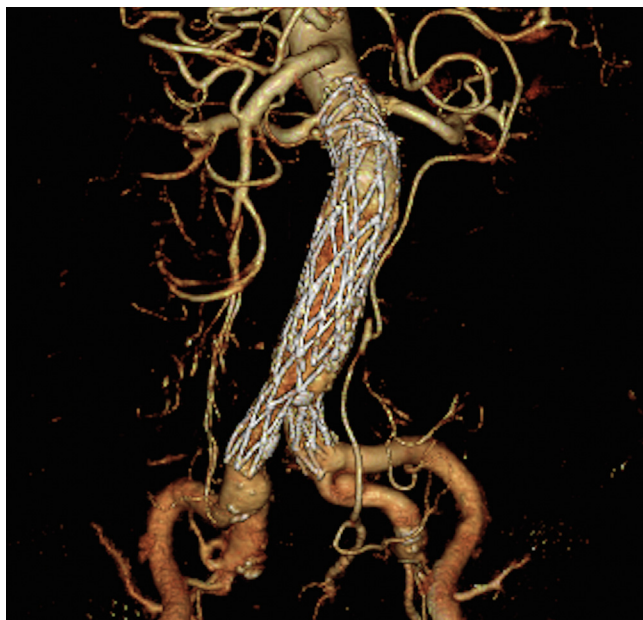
Postoperative contrast-enhanced computed tomography findings. A 27 × 38-mm size Aorfix proximal extension was added. The renal artery orifice is preserved, and there are no findings suggestive of stenosis.
